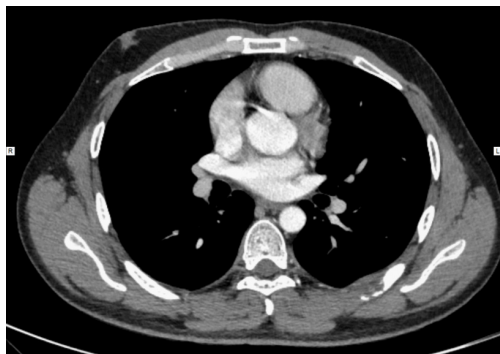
Enhanced CT scan of the patient's chest.
